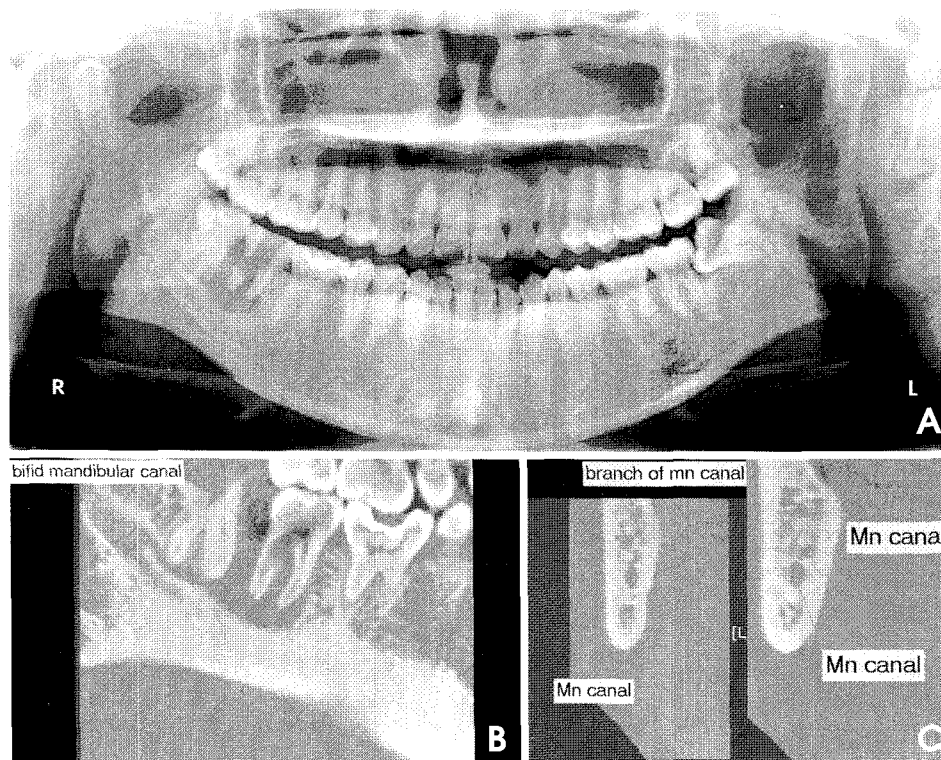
A, On the panoramic image, it is hard to detect any bifid mandibular canal. B, C, CT images show narrow upper branch canal along the roots (#38).
